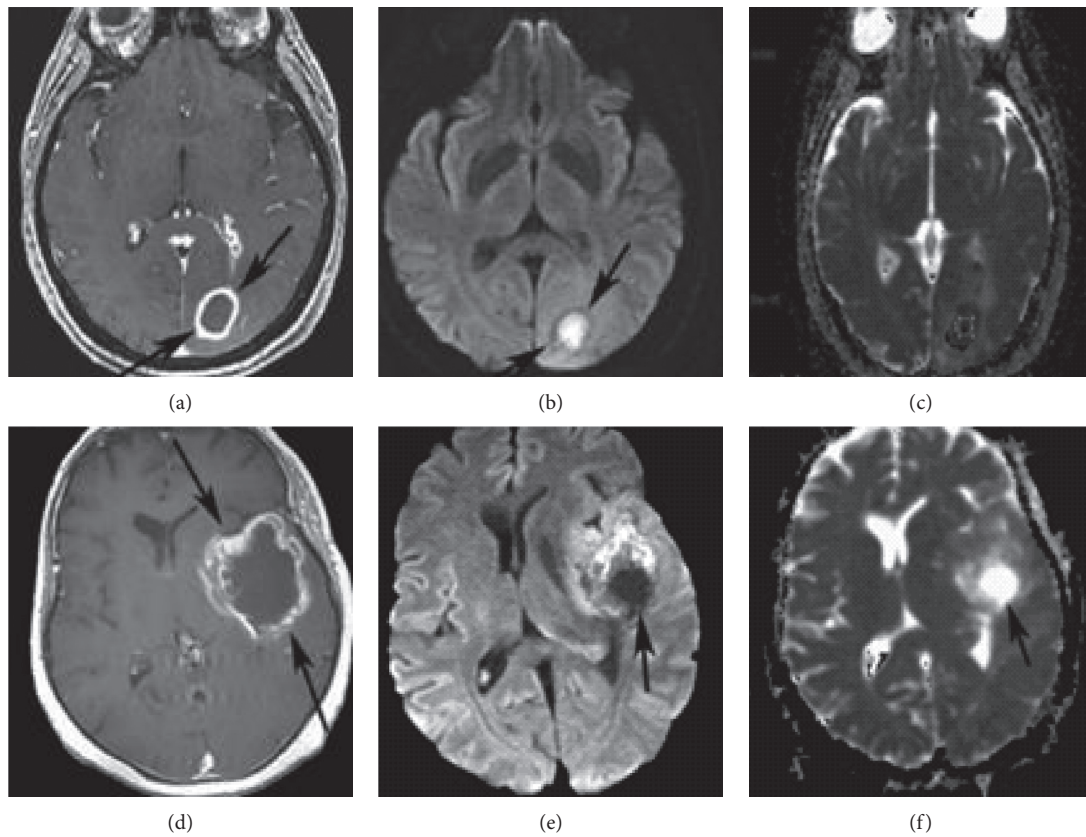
An MRI image of intracranial abscess foci accompanied by tumor necrosis. The abscess focus of the left occipital lobe showed circular  $T_1$  enhanced signals (a), DWI high signal (b), and ADC low signal (c). The glioblastoma in the left insular lobe showed irregular  $T_1$  circular enhancement (d), low DWI signal (e), and high ADC signal (f).
